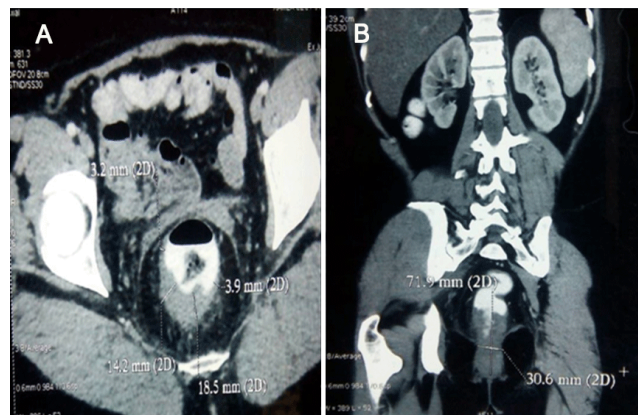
(A) Computed tomography scan of abdomen in axial section showing semi-circumferential mass lesion in anorectal region predominantly involving posterior wall; (B) computed tomography scan of abdomen in coronal section showing 71.9 mm mass lesion in anorectal region
